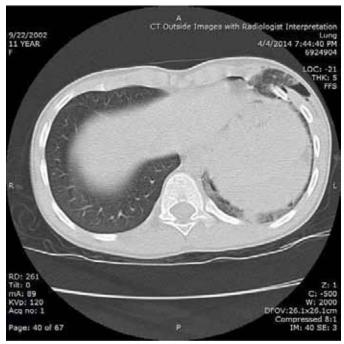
Chest computed tomography scan demonstrating rib fractures and lung herniation.
